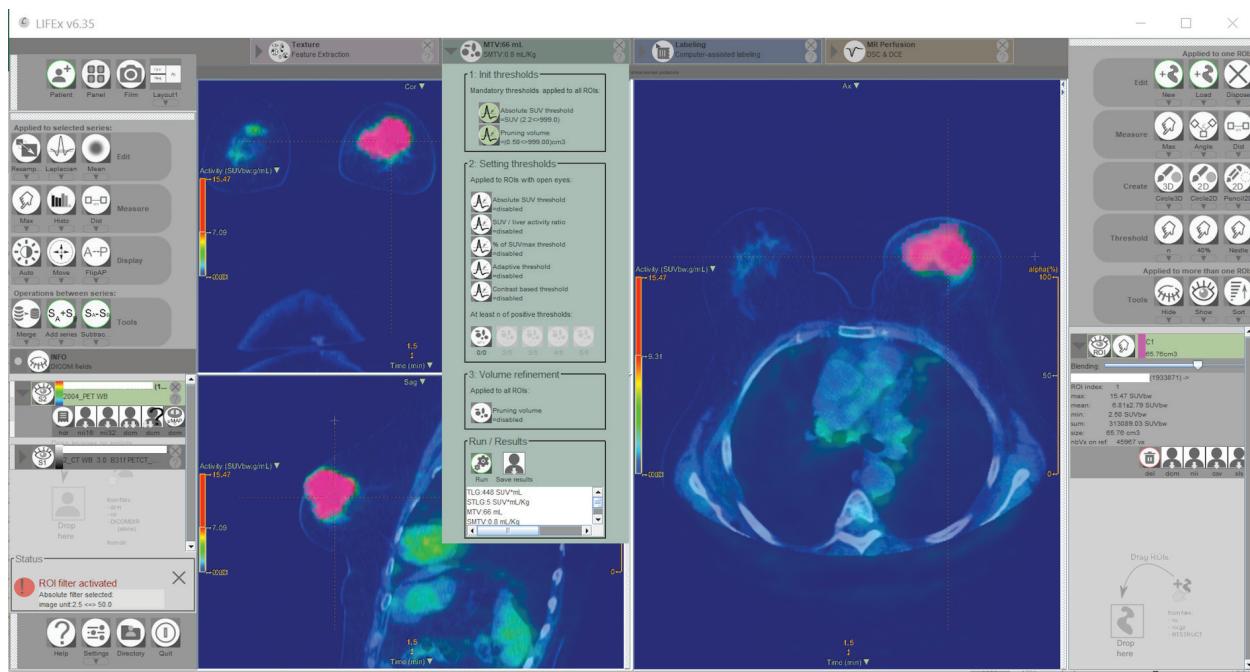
LIFEx software was used to obtain metabolic tumor volume and total lesion glycolysis and SUV average of primary tumor and axillary lymph nodes
